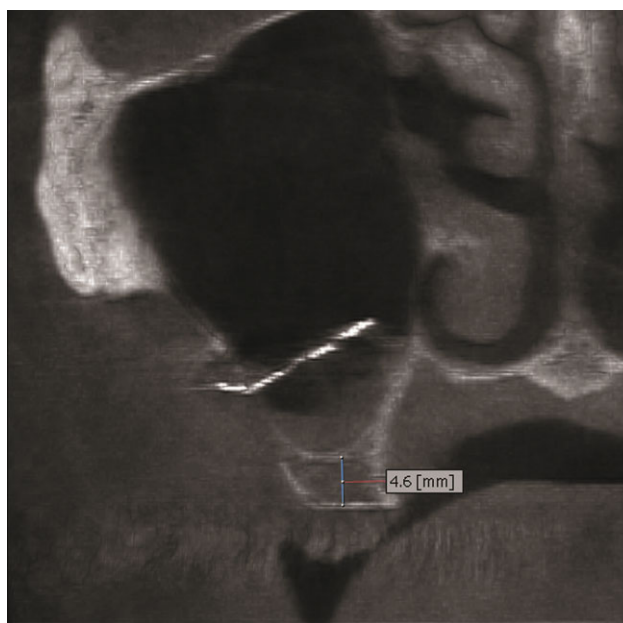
Reformatted cross-sectional view from the immediate postoperative CBCT of case (1), showing the distance between the crest of the ridge and the floor of the sinus.
